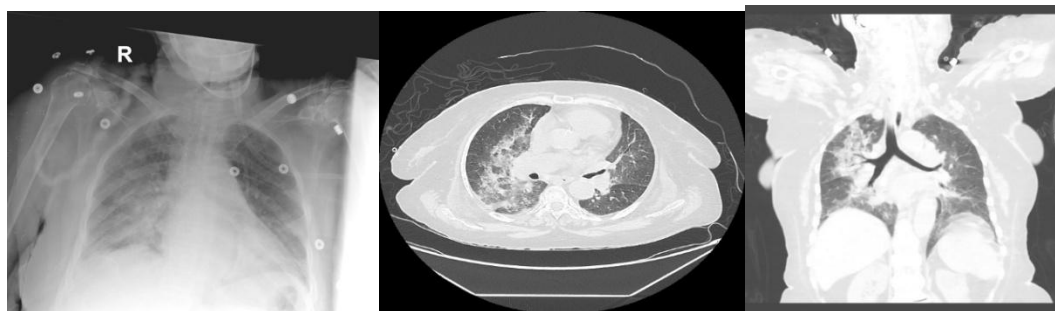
patient's initial computed tomography (CT) scan Notable for bilateral, patchy, and diffuse ground glass opacities
